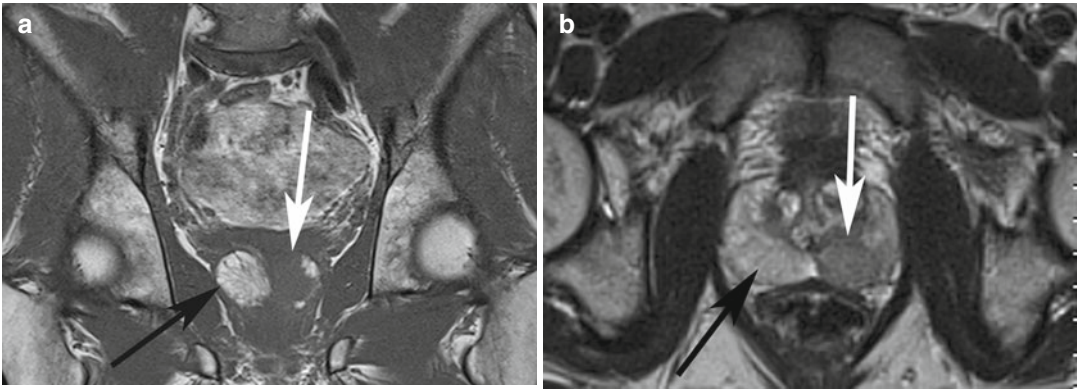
(a) Coronal T1-W MR image taken 3 weeks post-prostate biopsy shows a large area of high signal intensity consistent with an area of hemorrhage (black arrow). The tumor (white arrow) is of low signal intensity.
